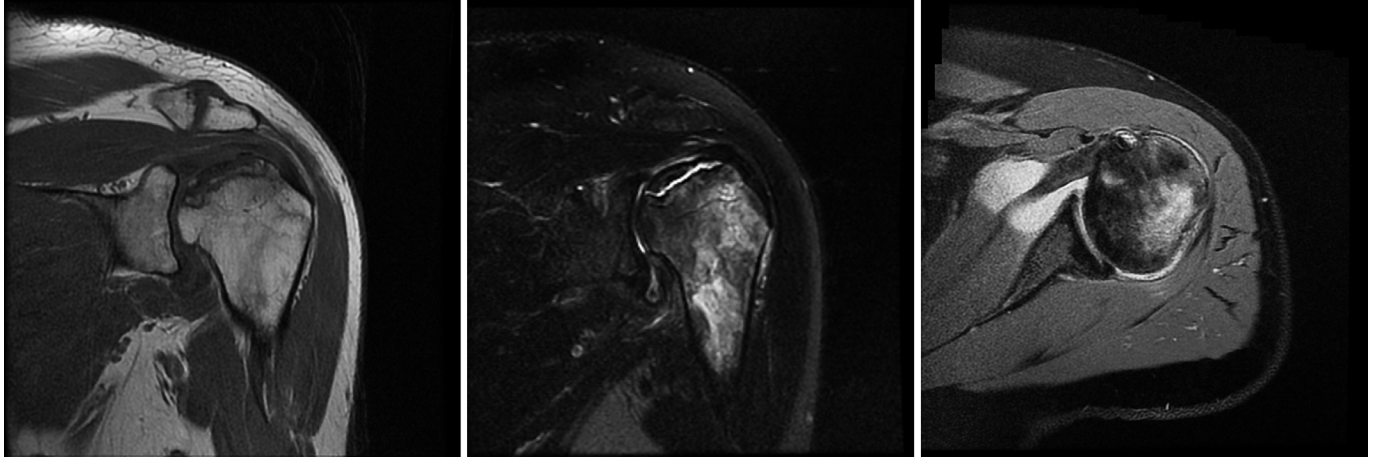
MRI Scan of the left shoulder showing subchondral sclerosis and fracture with bone marrow oedema extending to the proximal humeral shaft. These findings are in keeping with AVN. From left to right; Coronal T1 weighted slice, Coronal T2 weighted slice, Axial proton density fat saturation image.
